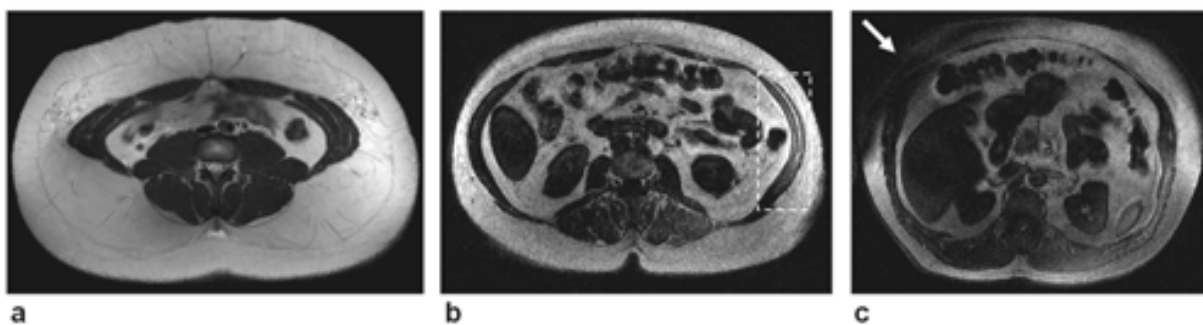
Frequency-selective MRI. Three slices are shown acquired at (a) 1.5T, and (b, c) 3.0T. In (a), SAT and VAT exhibit high signal intensity, in contrast to water-dominant muscles and organs. In (b), the dashed box encloses the left oblique and transversus abdominis muscles. There is appreciable signal from the muscles, in comparison to the darker right side. Due to  $B_0$  inhomogeneity, selective-fat-excitation was ineffective in this region. In (c), performance is severely hindered in the right anterior SAT region (arrow). Significant  $B_0$  inhomogeneity has caused the selective-fat-excitation RF pulse to *suppress* fat signal.
